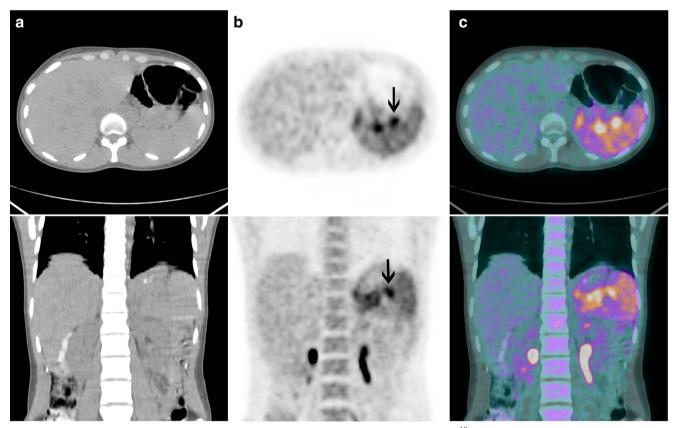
Patient 1. Transaxial and coronal (a) CT, (b) PET and (c) PET/CT fusion images show intensely <sup>18</sup>F-FDG-avid lymph nodes in the splenic hilum (*arrows*) and diffusely increased <sup>18</sup>F-FDG uptake in the spleen
